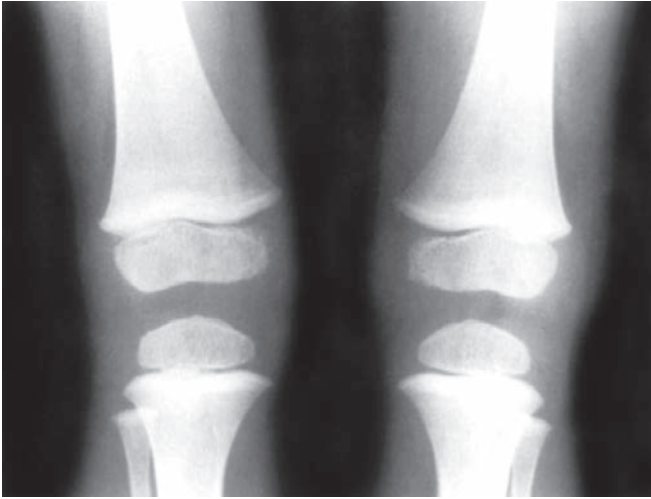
Radiograph of lower limbs in chronic lead poisoning. Note bands of increased density "lead lines" at metaphyseal ends of the long bones
